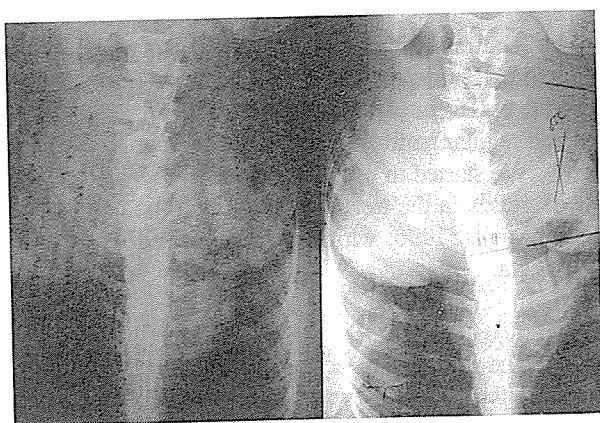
Radiographs of a 14 years old girl taken
